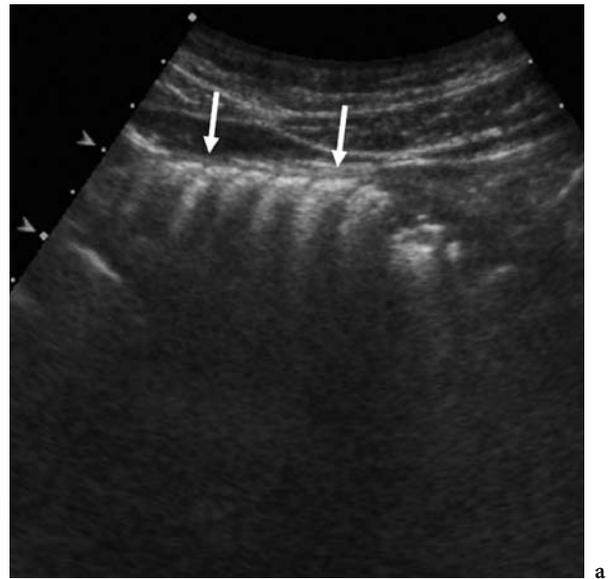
Gas-filled distended bowel loops. a Sonogram of the gas-filled jejunum shows air trapping in the valvulae conniventes (*arrows*). b Sagittal sonogram along the right side of the abdomen shows gas-filled, distended ascending colon. Note a haustral indentation (*arrow*)
